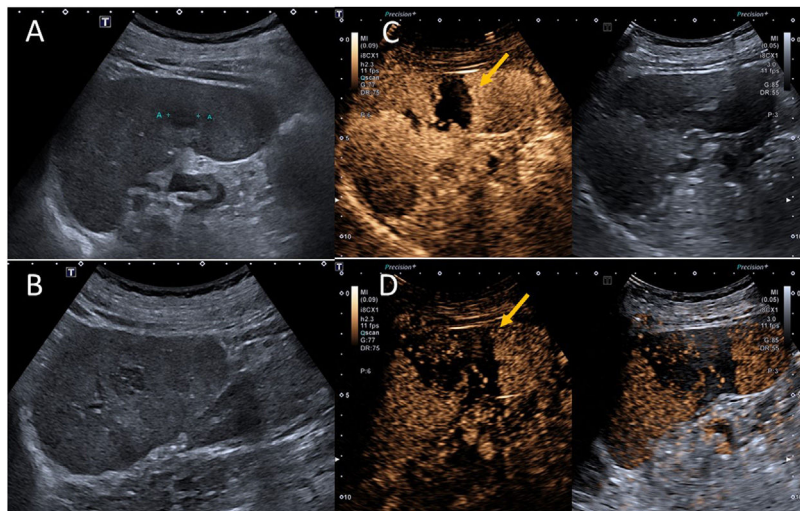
79-year-old male with vascular disease, with acute pain in the left hypochondrium. (A and B) Baseline greyscale ultrasound showing a 13-mm focal splenic lesion of heterogeneous appearance (between cursors in A). (C and D) Ultrasound after contrast at 60seconds (C) and contrast-B-mode fusion images at 120seconds (D) showing a large area of absence of contrast with wedge-shaped morphology (yellow arrows), compatible with a splenic infarction.
